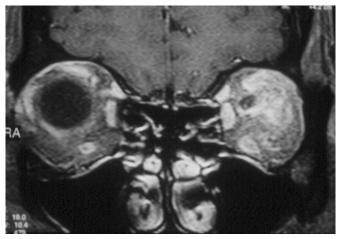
Coronal T1-weighted, gadolinium-enhanced orbital magnetic resonance imaging in a patient with acuteonset, painful diplopia and decreased vision in the left eye. The magnetic resonance imaging demonstrates diffuse enhancement of the left orbit consistent with orbital pseudotumor. Symptoms improved with steroid treatment.
